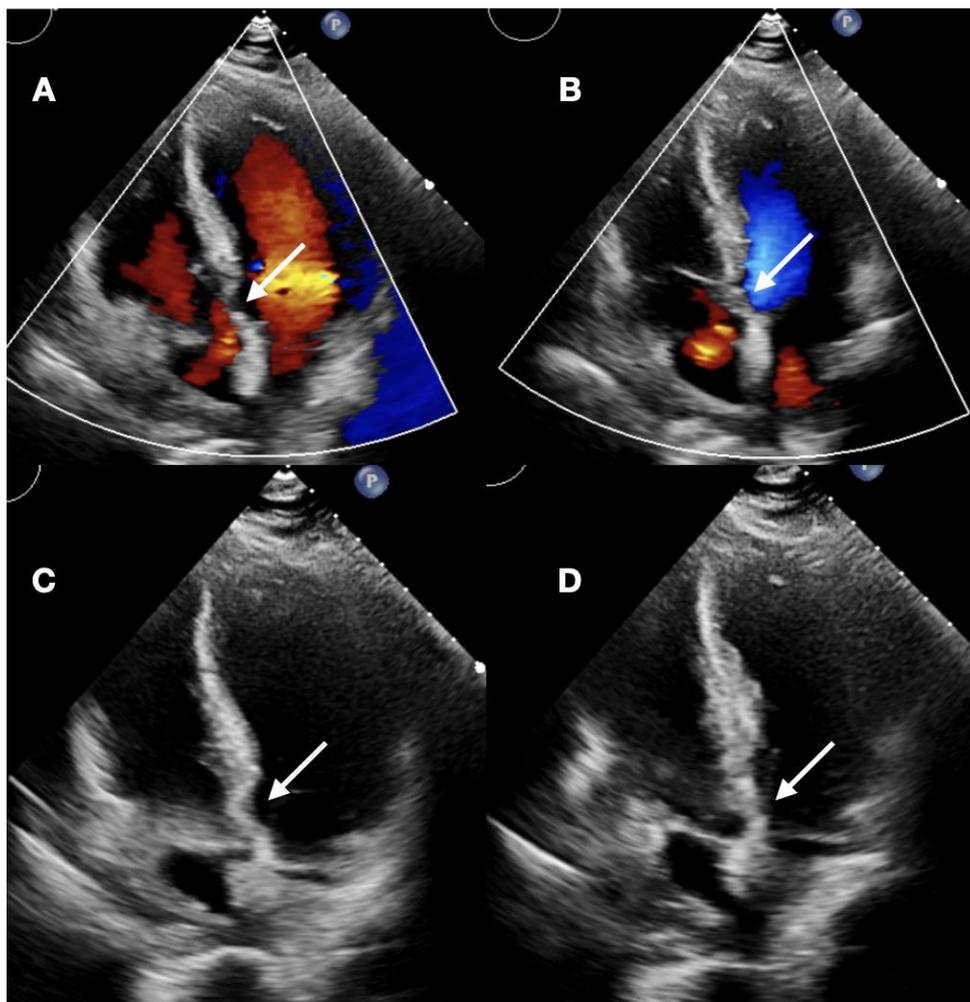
TTE showing a ventricular defect from (apical 4-chamber view)
